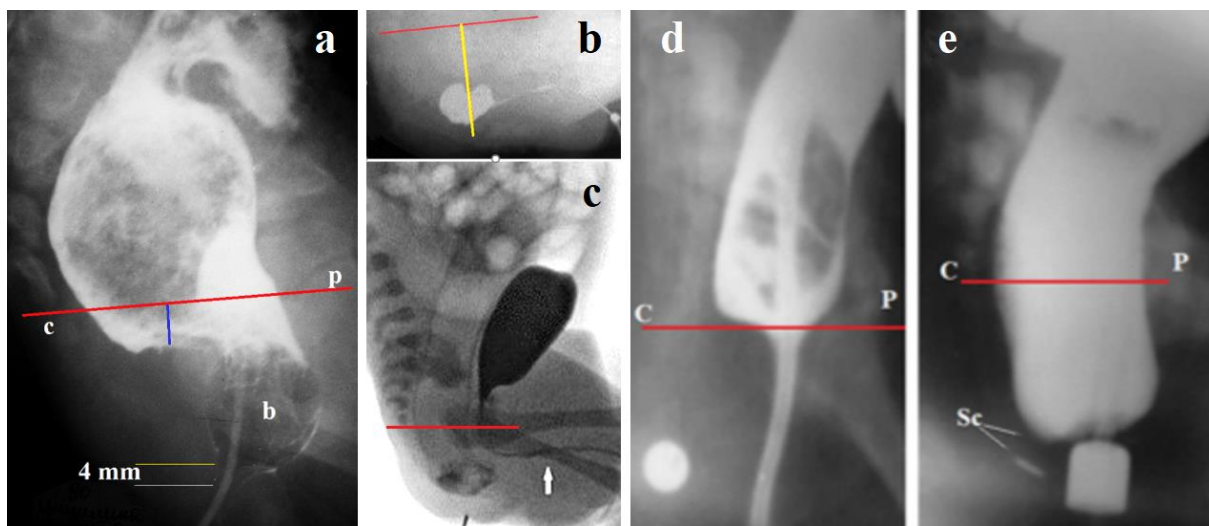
Radiographic studies of ARMs with visible fistulas (low-type).
